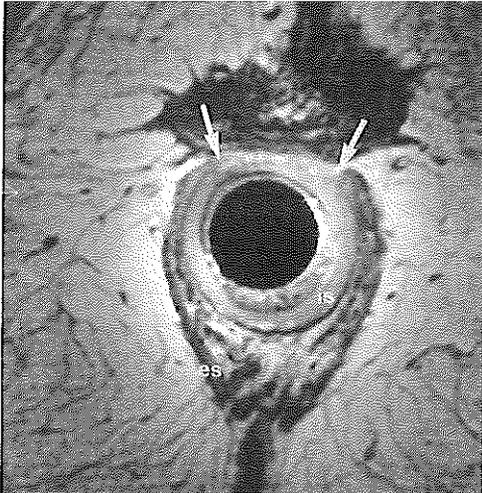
Endoanal axial proton density gradient-echo MRI (30/13) of a 40 years old female patient with fecal incontinence showing subtle decrease of the signal intensity and altered texture (arrows) of the external sphincter (ES) which was diagnosed as scarring. The surgery did not validate this finding. Internal sphincter (IS).
